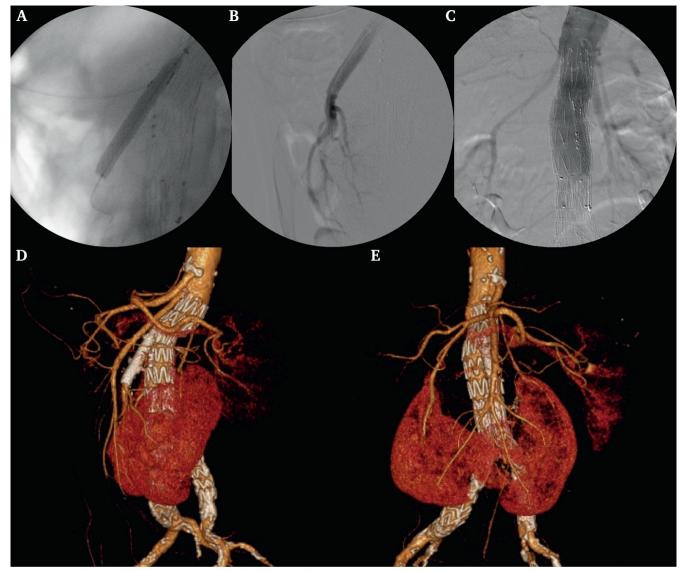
Procedure and results. A. Polar artery branch stent deployment. B. Branch angiography. C. Intra-operative angiography control. D and E. Post-operative 3D computed tomography angiography reconstruction.
